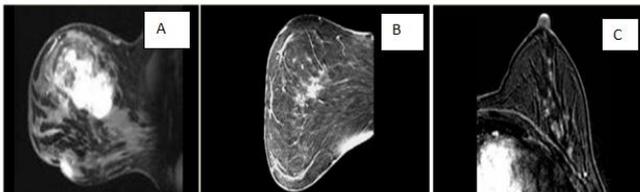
Examples of MRI images A) Mass with an irregular shape B) Non-mass enhancement C) Little bright objects: Foci
